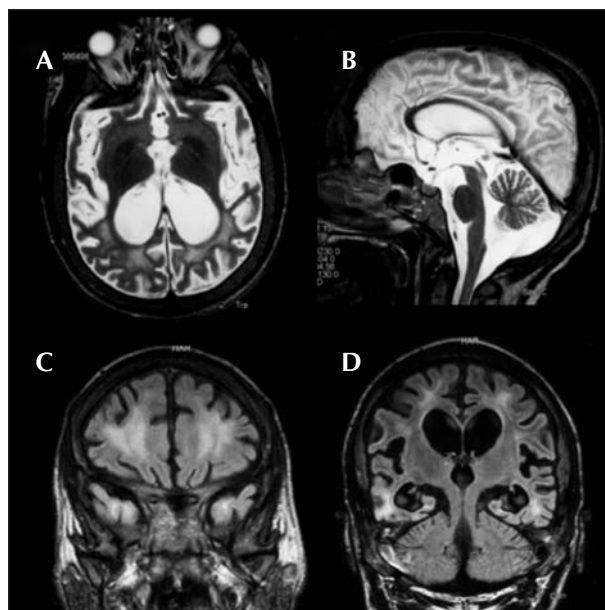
MRI scan at age 18 years. A) T2w axial image demonstrating progressive cerebral atrophy. White matter signal is hyperintense. B) T2w sagittal image. The cerebellar vermis is slightly atrophic, but not to the same extent as the supratentorial structures. C) and D) coronal FLAIR images demonstrating hyperintense white matter signal including subcortical white matter in both temporal lobes and severe supratentorial atrophy.
